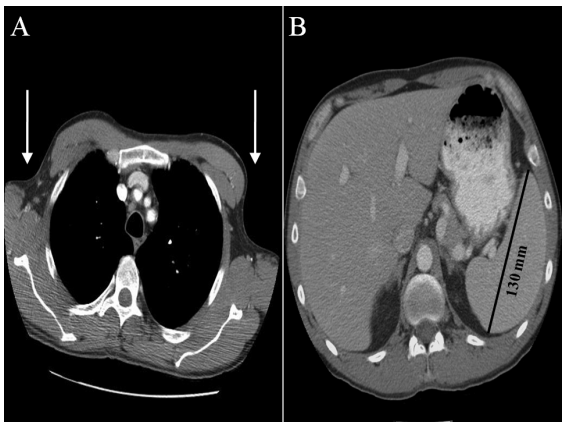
Computed tomographic (CT) scan of the body done 2 weeks after the last cycle of chemotherapy revealed a complete resolution of splenomegaly and lymphadenopathy in the neck, axilla, mediastinum, and retroperitoneum. The figure shows the complete resolution of bilateral axillary lymphadenopathy (white arrows) (A) and regression of splenomegaly (B).
